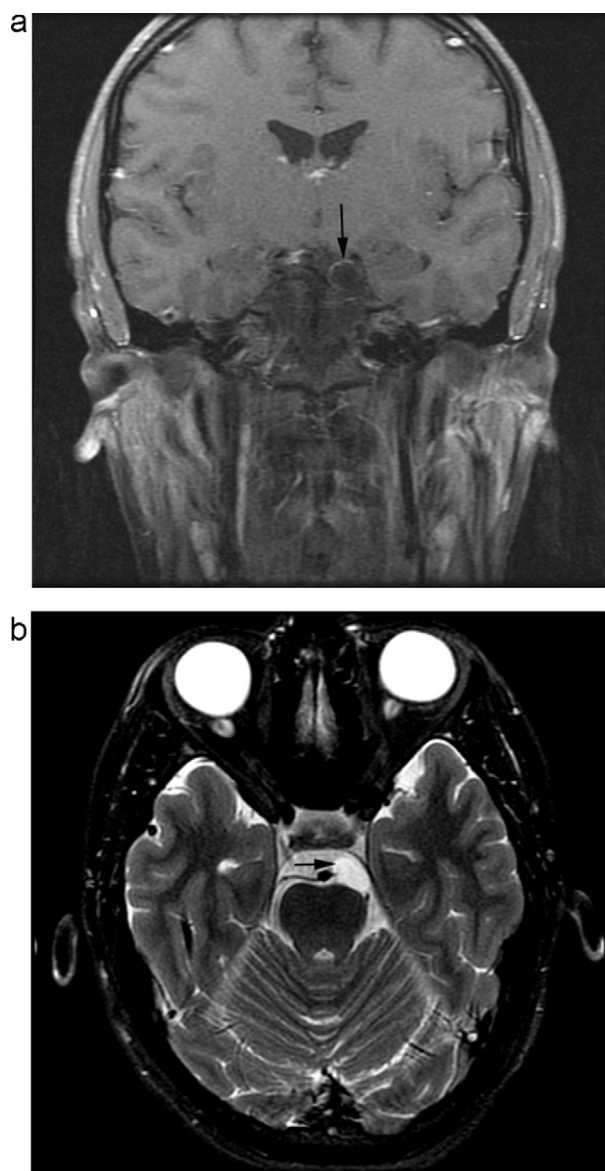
Magnetic resonance images of the endodermal cyst of the oculomotor nerve. Location, walls and anatomical relationships of the cyst may be precisely appreciated (arrows). (a) Coronal view. (b) Axial view.
